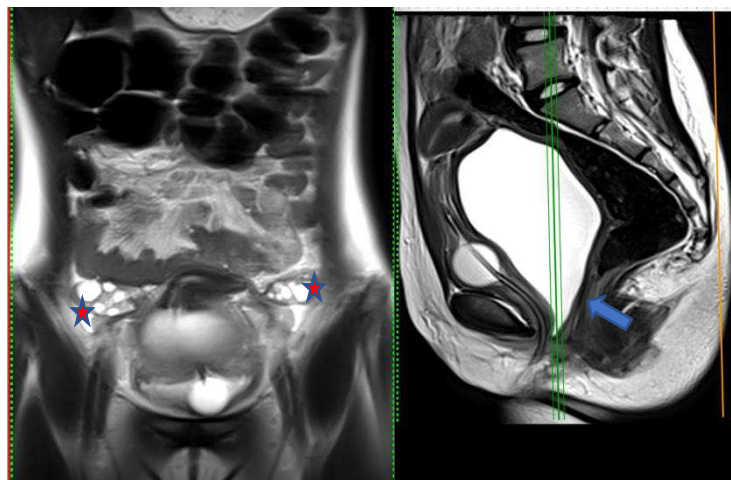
a 15-year-old female patient with ASRM type transverse vaginal septum on MRI t2 coronal sagittal shows a hyperintense collection in the endometrial cavity, the upper two-thirds of the vagina and a thick septum separating the upper two-thirds of the vagina from the lower 1/3 with bilateral ovaries that still look normal .
